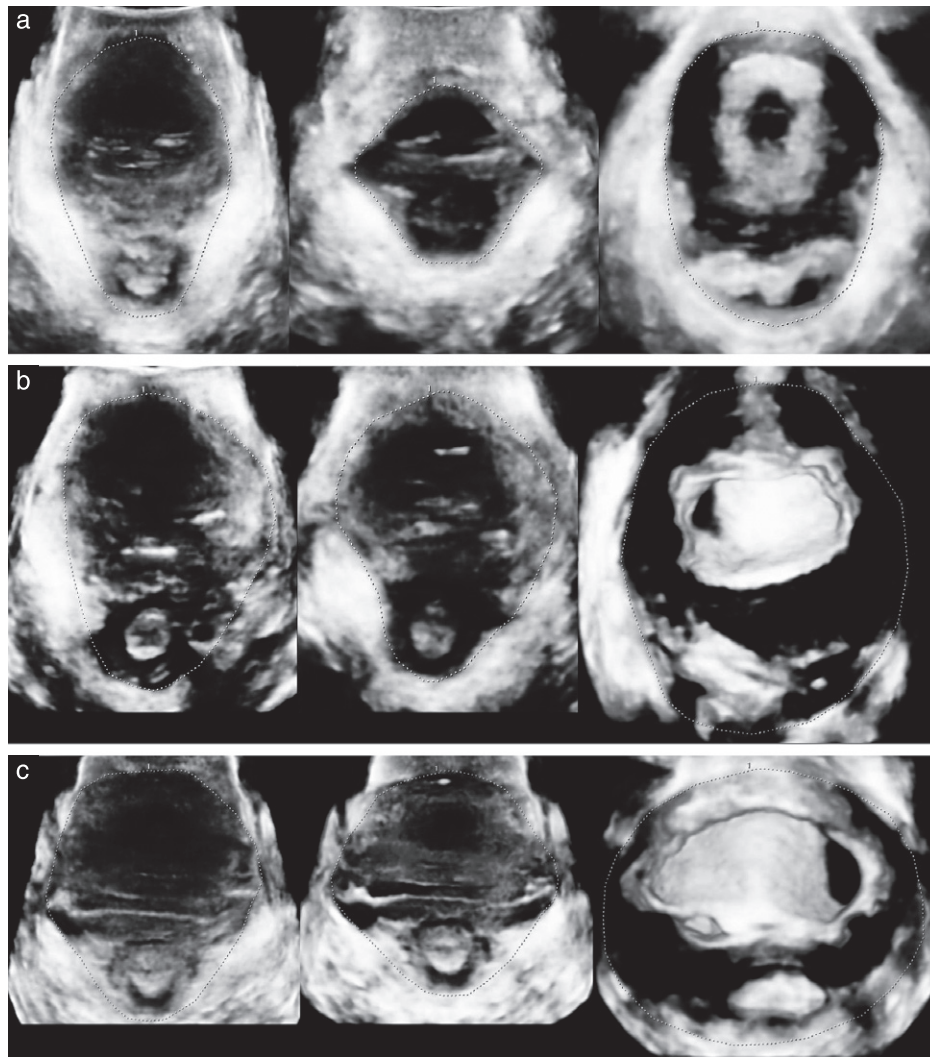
Tomographic ultrasound images of hiatal areas at rest, on pelvic floor muscle contraction and on Valsalva maneuver in women with: (a) intact levator (19.7, 9.6 and 23.8 cm², respectively), (b) unilateral avulsion (27.3, 19.8 and 46.1 cm², respectively) and (c) bilateral avulsion (27.3, 25.6 and 47.3 cm², respectively).
